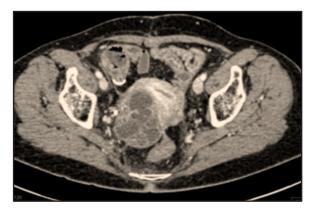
CT scan showing right adnexal mass.
